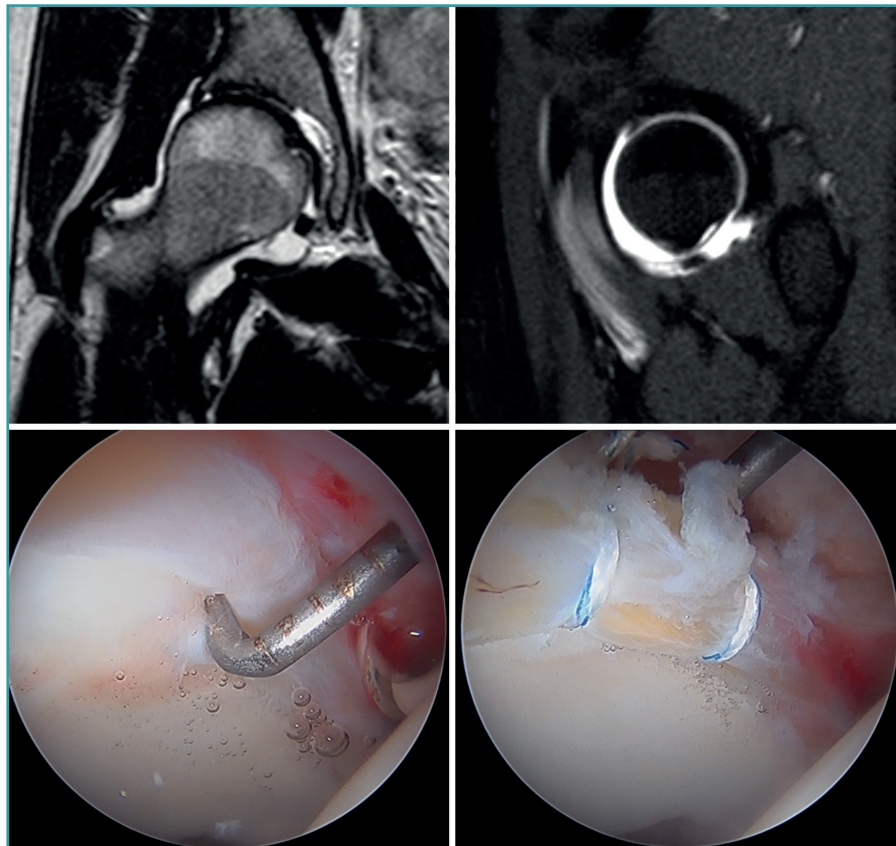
Chondrolabral injury in a young female patient. At top, coronal and sagittal views of the preoperative MRI study, showing the chondrolabral junction lesion in the anterosuperior region. At bottom, intraoperative details of the chondrolabral lesion (left) and after stabilisation (right).
